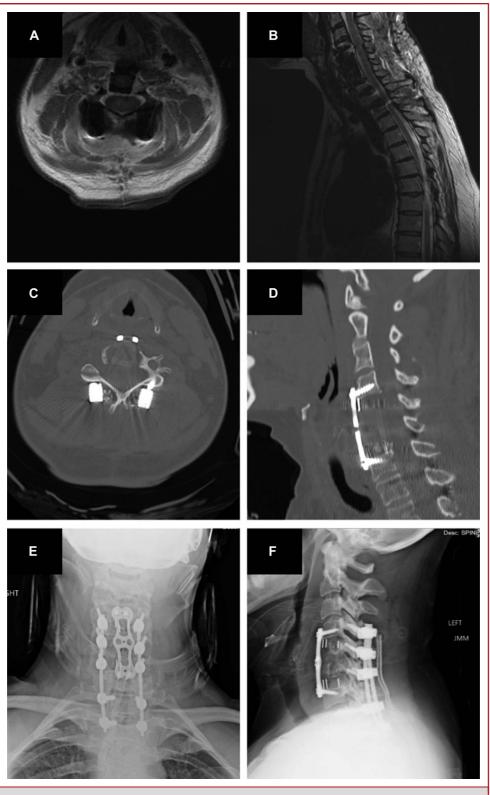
Postoperative cervical MRI A, and B, computed tomography C, and D, and upright x-ray imaging E, and F, demonstrating tumor gross total resections and anterior cervical 5/6 corpectomy and posterior cervical 4 thoracic 2 instrumented fusion.
